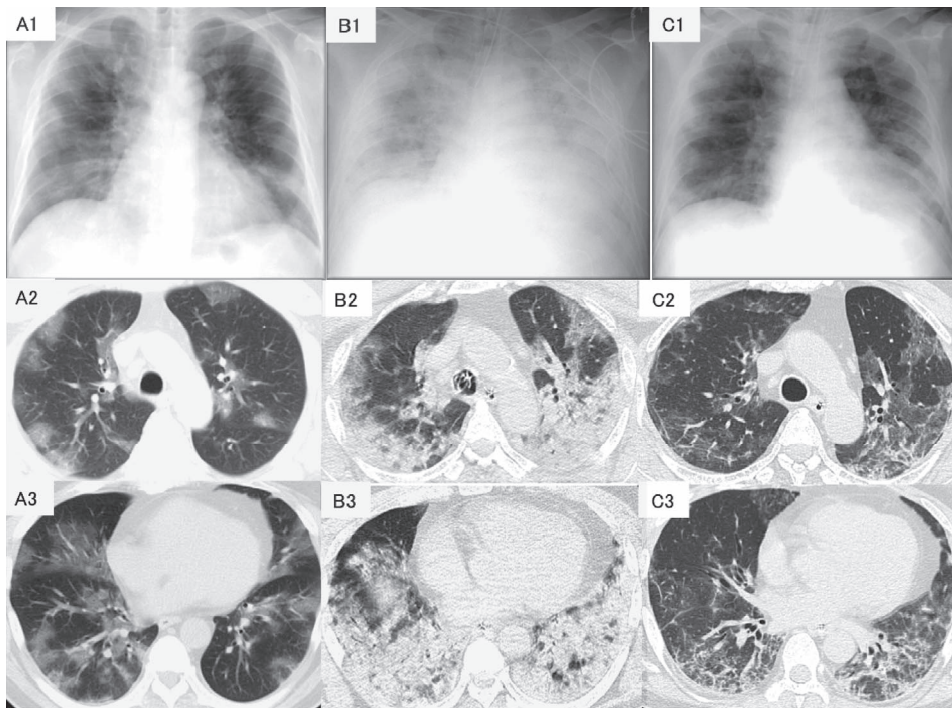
A: Chest radiograph (A1) and CT (A2 and 3) on the first admission to A hospital, showing patchy ground-glass attenuations in bilateral lungs. B: Chest radiograph (B1) and CT (B2 and 3) on the transfer day to our hospital, showing exacerbated diffuse infiltrates, consolidations and ground-glass attenuations in bilateral lungs. C: Chest radiograph (C1) and CT (C2 and 3) on day 12 after the transfer to our hospital, showing improved radiological findings with patchy ground-glass attenuations in bilateral upper lung fields, and linear and reticular opacities in bilateral basilar lung fields.
